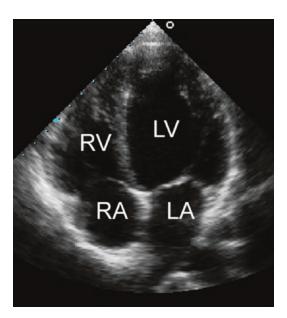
A properly angled apical four-chamber view is shown with the chambers labeled. Adult echocardiographers display the apical views with the ventricles on to as shown. Most pediatric laboratories will electronically invert the apex so that the display is anatomically correct
